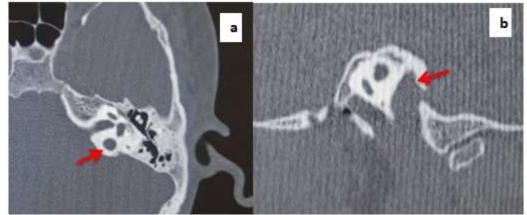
Axial and Sagittal CT images showing high riding Jugular bulb (arrows in a and b)
